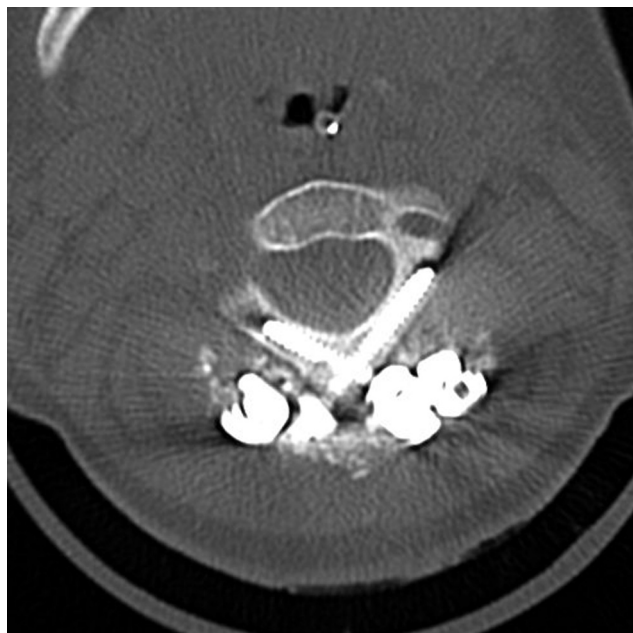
Postoperative computed tomography scans show 22- and 20-mm screws with good cortical purchase in the axis lamina, and placed at a safe distance from the vertebral artery.
